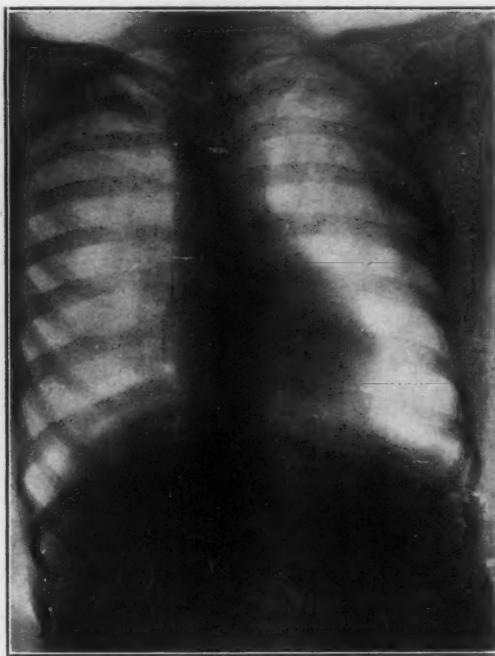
Radiograph by Dr. Lewis G. Cole, showing two tacks in a posterior branch of the right inferior lobe bronchus. Tacks removed by bronchoscopy through the mouth. (Reprinted from Journal Amer. Med. Ass'n, Sept. 25th, 1909.)
